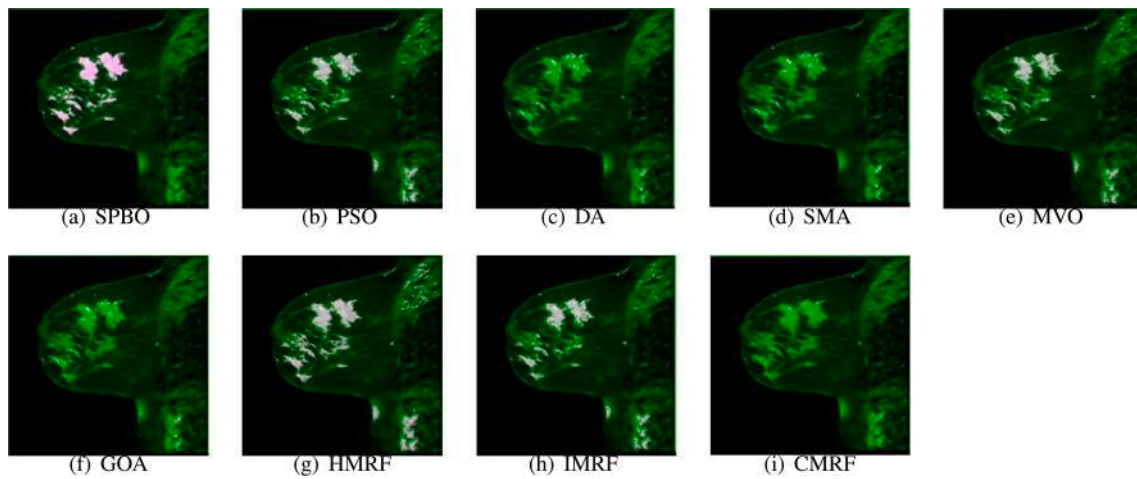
Localized lesions (bright colored spot) in MR images for patient-2 (a) SPBO, (b) PSO, (c) DA, (d) SMA, (e) MVO, (f) GOA, (g) HMRF, (h) IMRF, and (i) CMRF.
